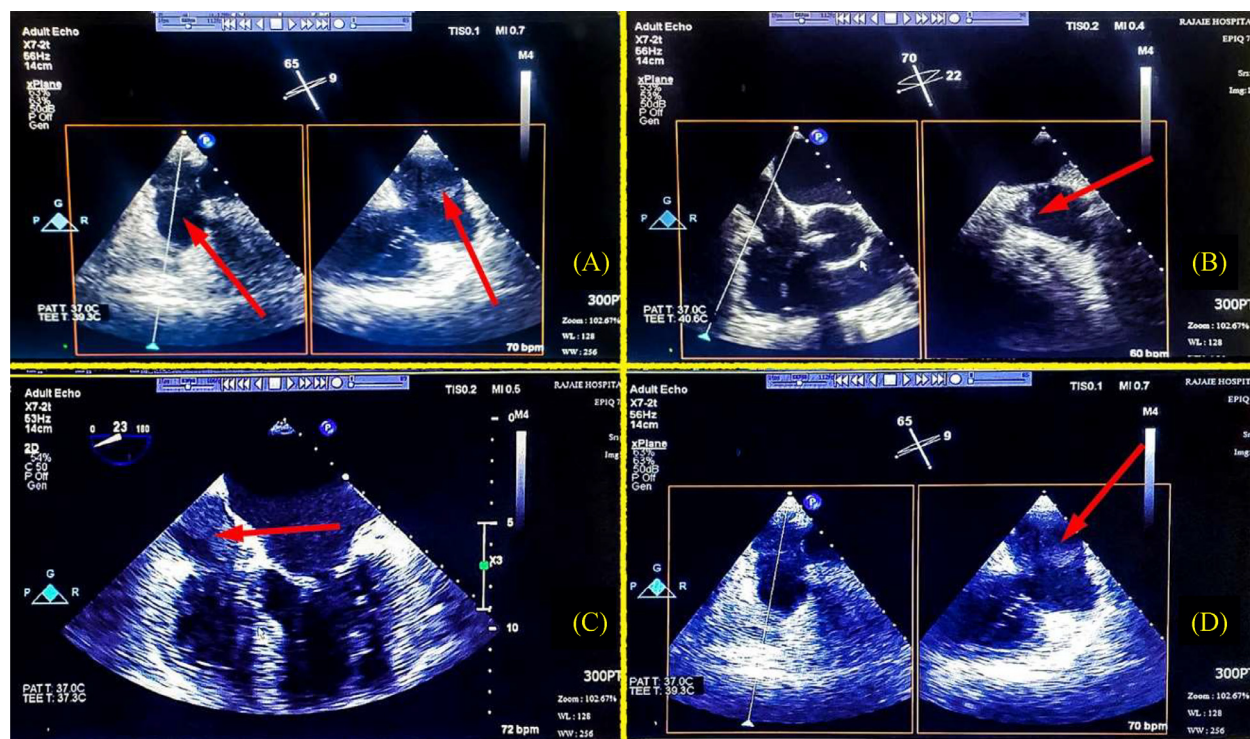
Echocardiography of cardiac lymphangioma. A large, semimobile, well-defined multilobulated, hypoecho mass in RA cavity causing turbulency but no significant gradient at the site of IVC entrance to RA.
